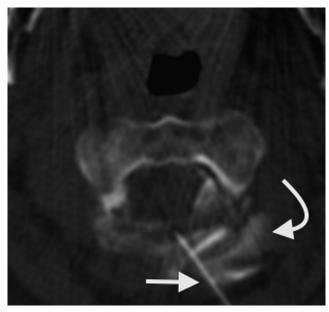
Axial CT image of the C1-C2 level shows advancement of spinal needle (straight arrow) with epidural contrast extravisation into the paraspinous soft tissues (curved arrow).
